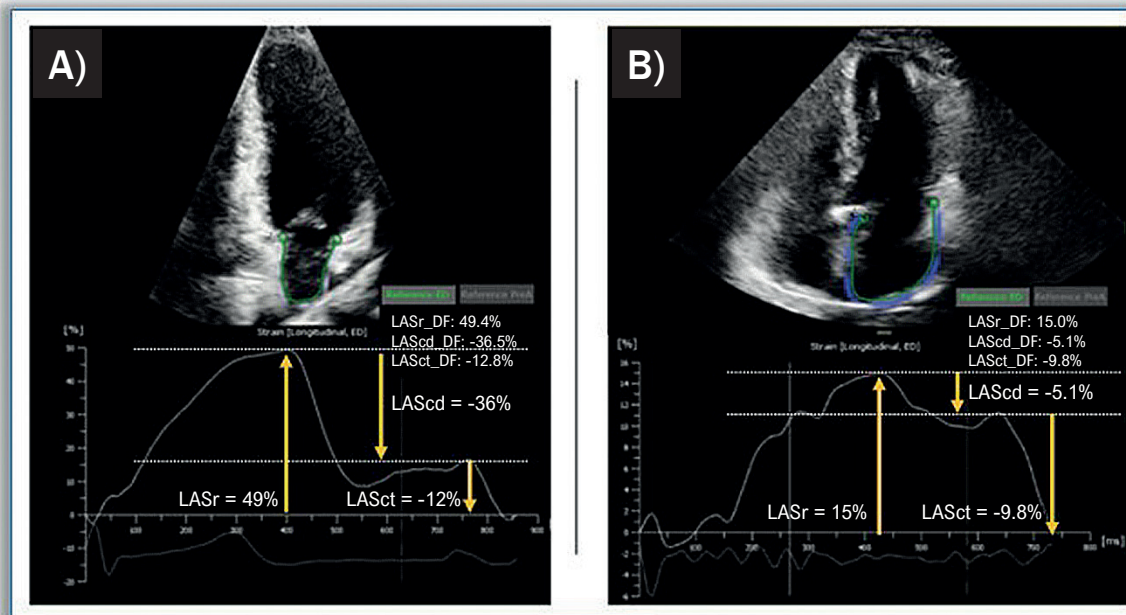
Role of LAS in refining the assessment of LV filling pressure. Assessment of LA deformation using speckle-tracking echocardiography. A) LASr, LAScd, and LASct measurements in a normal subject, with values of 49%, –36%, and –12%, respectively; B) corresponding strain curves from a patient with increased filling pressures, showing values of 15%, –5.1%, and –9.8%, respectively. LA: left atrium; LAS: LA strain; LAScd: LA conduit strain; LASct: LA contractile strain; LASr: LA reservoir strain; LV: left ventricle.
